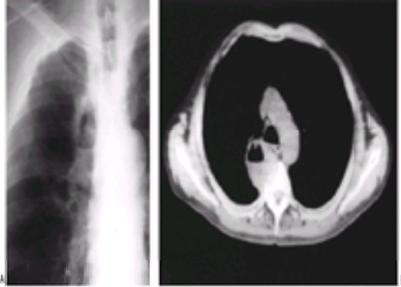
A: A large mass is present in the right paramediastinal area. An air-fluid level is present within the central cavitary portion of the lesion, defining its approximate inner and outer margins. A small projection into the cavity from the lateral wall suggests the possibility of necrotizing tumor. The diagnosis of squamous cell carcinoma was confirmed by bronchoscopy. B: On CT, the entire anterolateral aspect of the adjacent vertebral body has been eroded. Chest wall invasion may be readily apparent or completely undetectable on CT.
